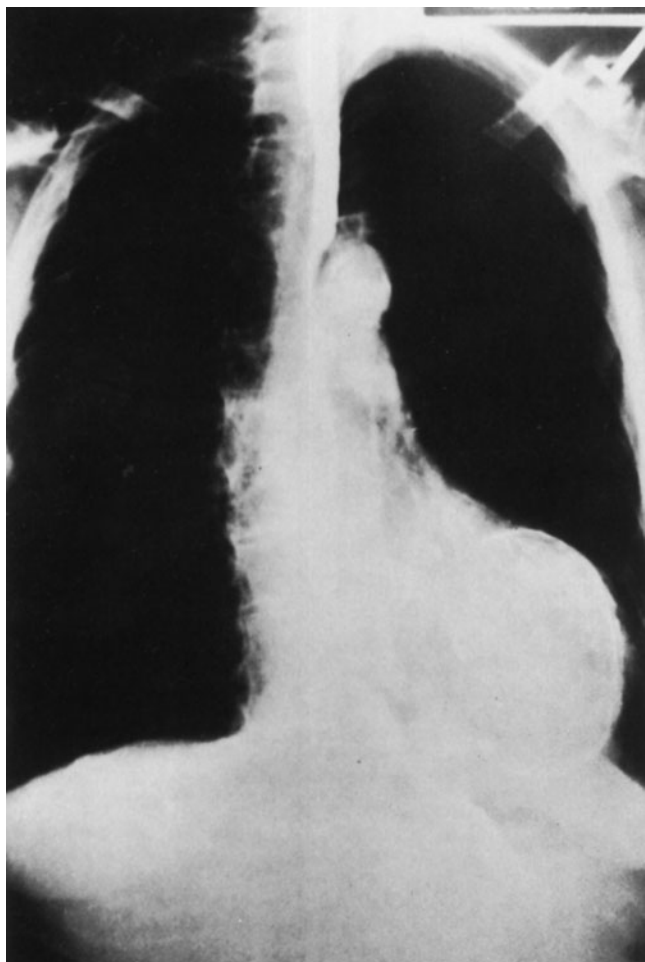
Posteroanterior chest radiograph in a patient with a calcified left ventricular aneurysm. (Reproduced with permission from Ba'albaki and Clements.⁴⁶)
